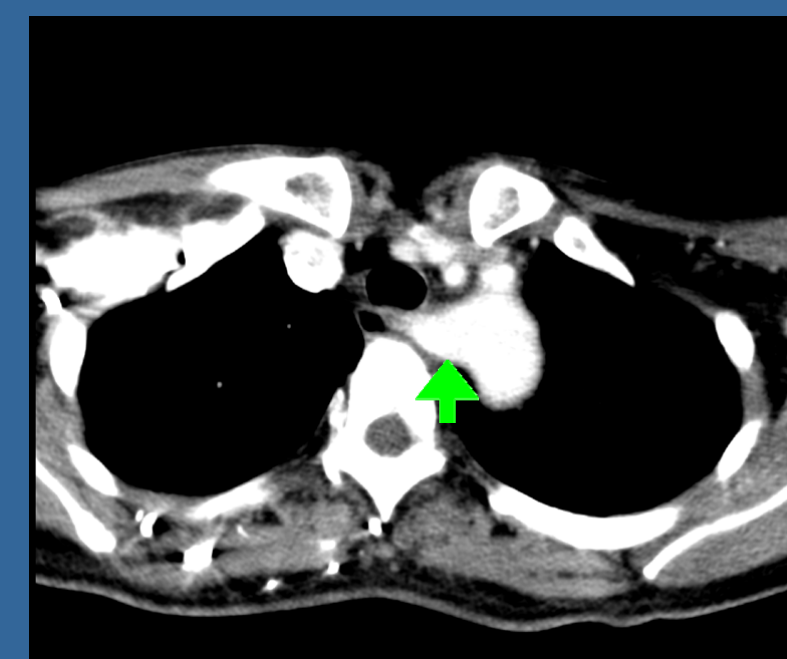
Arteria lusoria(arrow) on CT scan
